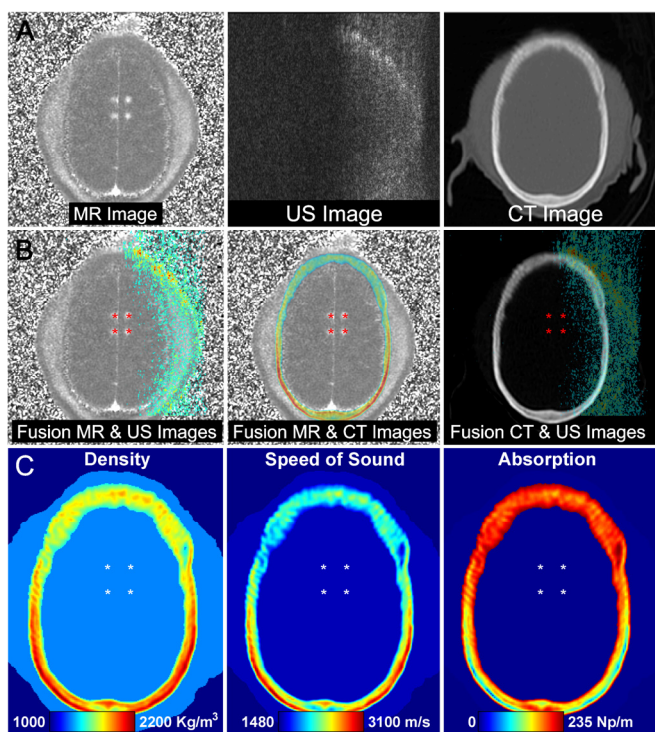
Three modality image registration and acoustic properties of the NHP head. (A) Axial MRI, b-mode US imaging, and CT of an NHP. The MRI shows a map of the percent change in signal after administration of a MRI contrast agent. Four enhancing targets show localized FUS-induced BBB disruption. (B) Fusion of different images. (C) Quantitative images showing the range of the acoustic parameters from the NHP at 0.88 MHz. Similar values were extracted from the clinical data (See table I). The four stars indicate the locations of the BBB disruption in the MRI.
